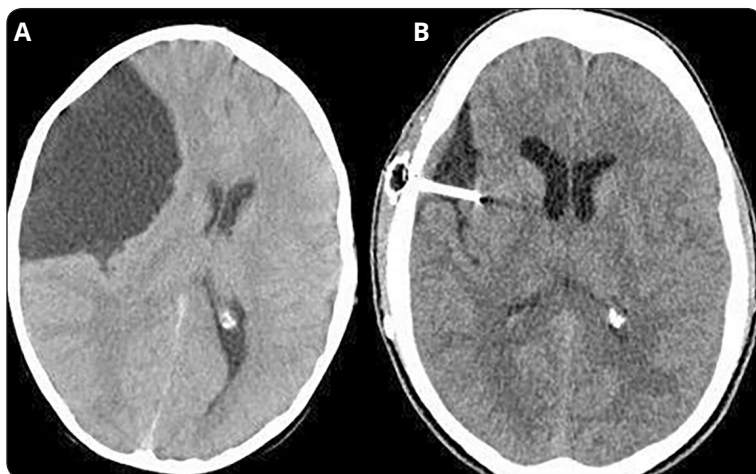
A CT scan of a Type III Sylvian cyst treated by cystoperitoneal shunt. B Postoperative CT showing cyst size reduction
